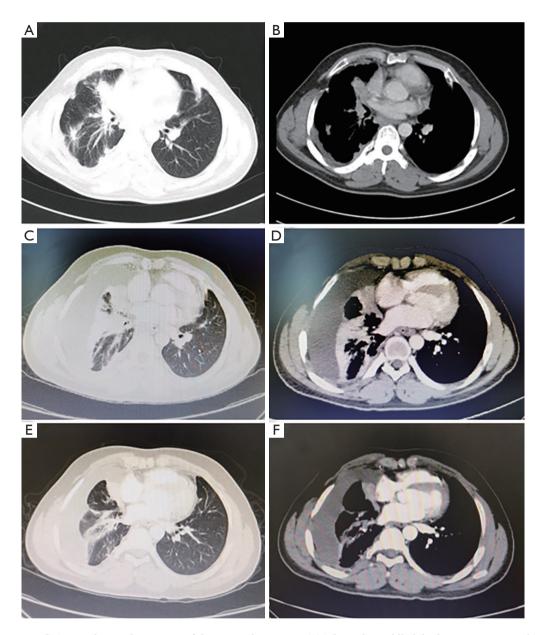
Changes in CT signs during the process of disease in the patient. (A) The right middle lobe lesion measuring about $3.5 \times 2.4 \text{ cm}^2$ and multiple patchy shadows under the right lung pleura; (B) local pleural thickness and adhesion, small amounts of pleural effusion, multiple enlarged lymph nodes in mediastinum and multiple cauliflower-like exostosis on both ribs; (C) repeat chest CT after treatment for 6 weeks with the right lung lesions similar to the former; (D) the thickened right visceral pleura and the increased right pleural effusion; (E) repeat chest CT after treatment for 12 weeks with the right middle lobe lesion measuring about $3.0 \times 1.7 \text{ cm}^2$; (F) pleural effusion slightly less than before.
